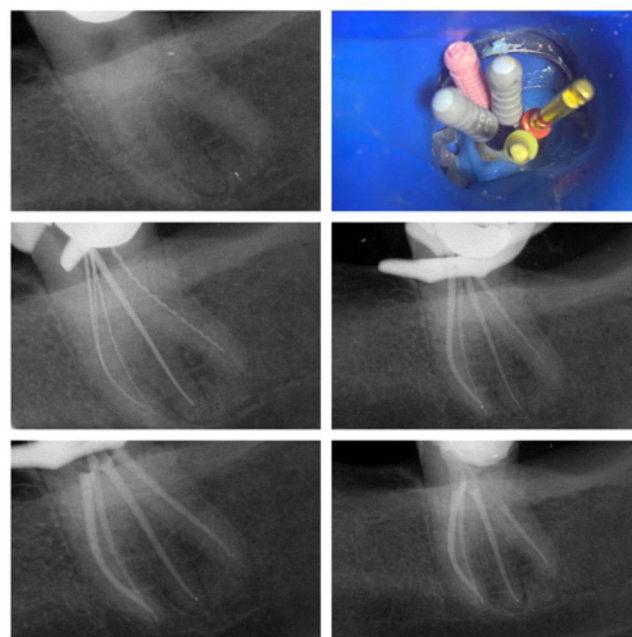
A. First diagnostic radiography; B. Working length determination under rubber dam; C. Verification of working length with rotary file; D. Verification of working length with gutta-percha; E. Radiographic image after obturation; F. Radiographic image after obturation without rubber dam.
